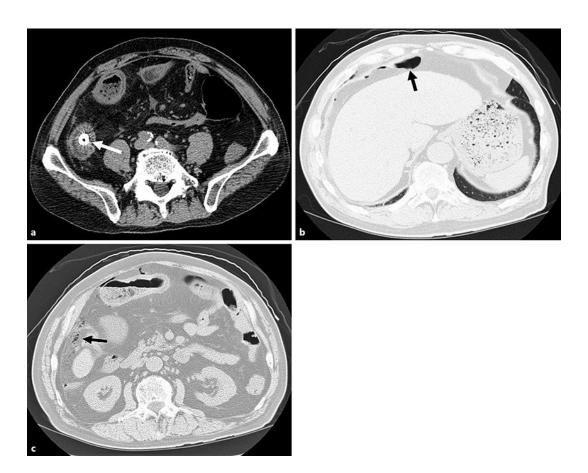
a An abdominal CT scan showing the trapped patency capsule in the patient's terminal ileum (arrow). b, c An abdominal CT scan showing the spreading of free air.
